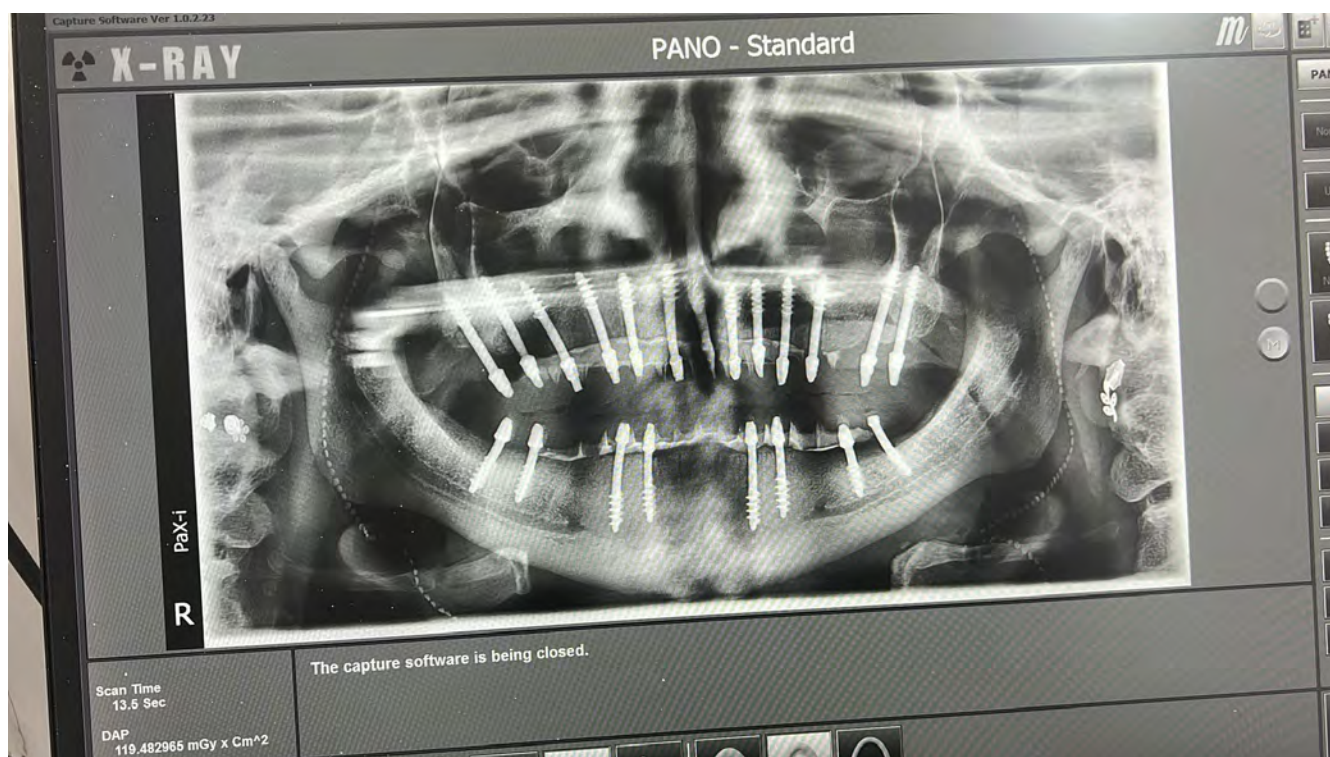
Two-year follow-up panoramic radiograph, showing cemented PMMA bridges in both jaws.
